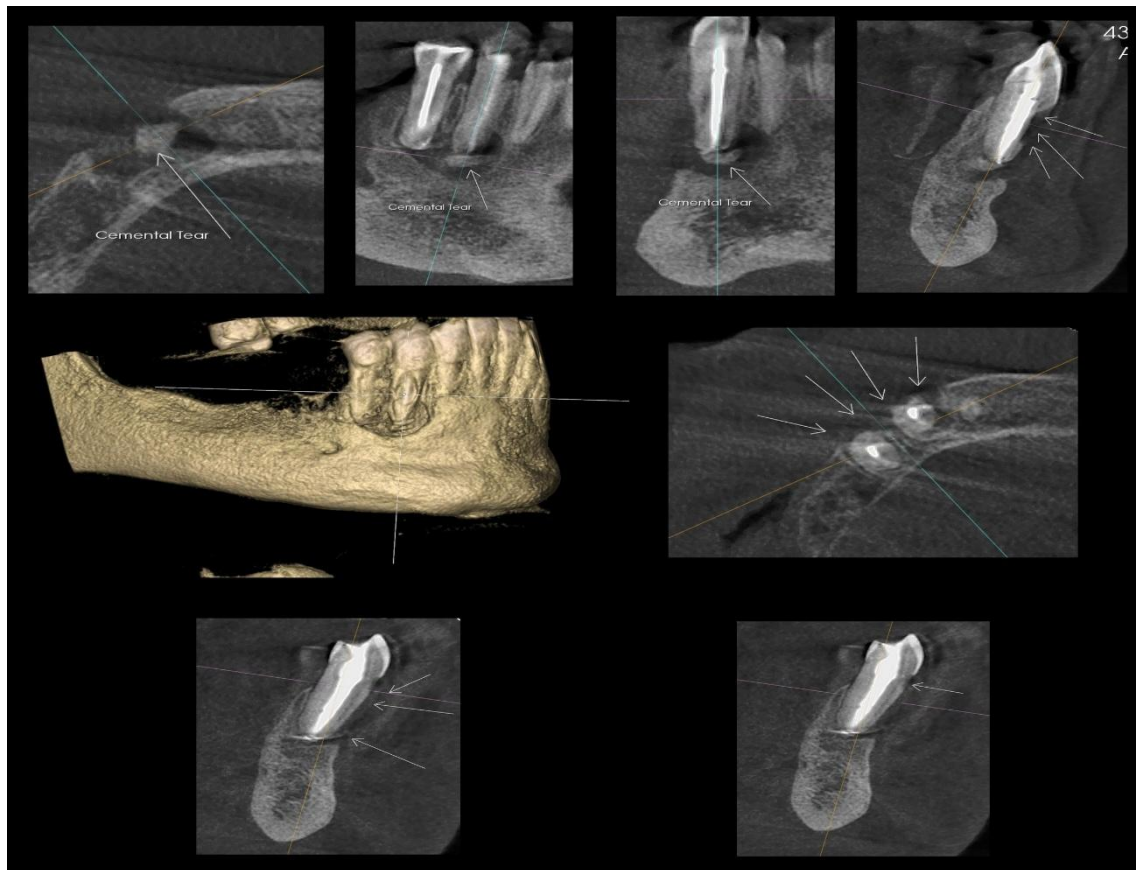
Cone beam computed tomography (CBCT) of the area showing alveolar bone loss in the periapical region of teeth 43 and 44.
